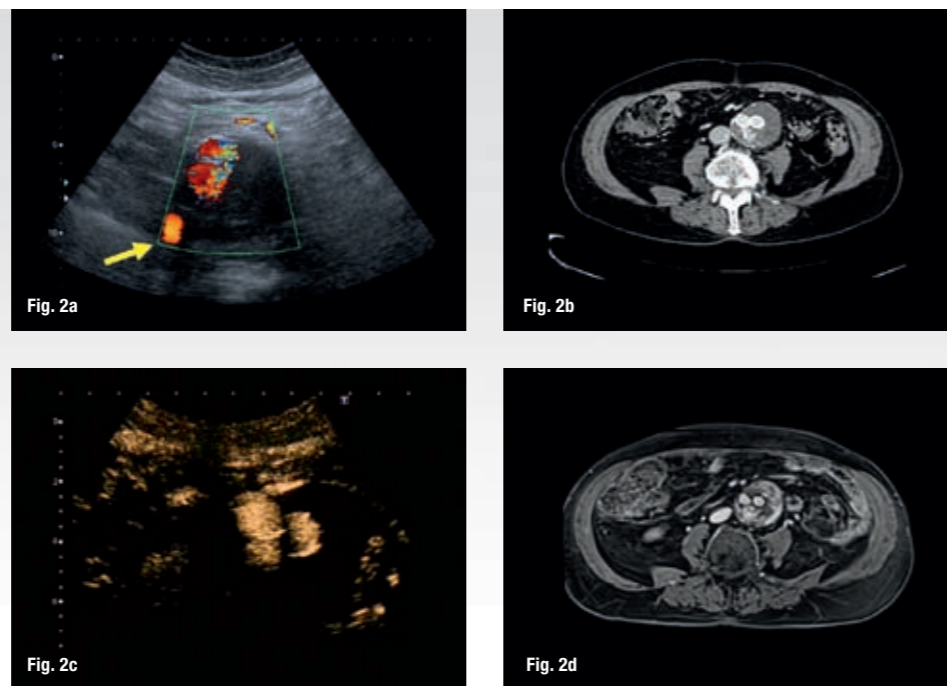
Color Doppler US (a) shows no flow within the aneurysmal sac; hypertrophic lumbar artery (arrow). Focal contrast-enhancement behind the iliac branches during arterial phase consistent with II-type endoleak was detected at CTA (b), MRA (c) and CEUS (d).
